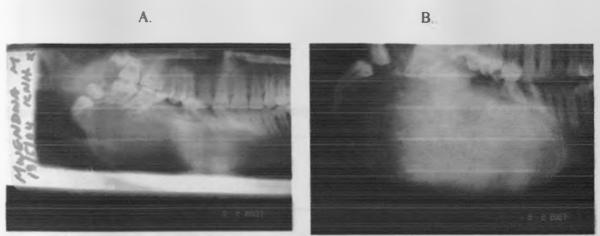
Contrasting radiographic features of OF at initial presentation (A) and one year later (B).
